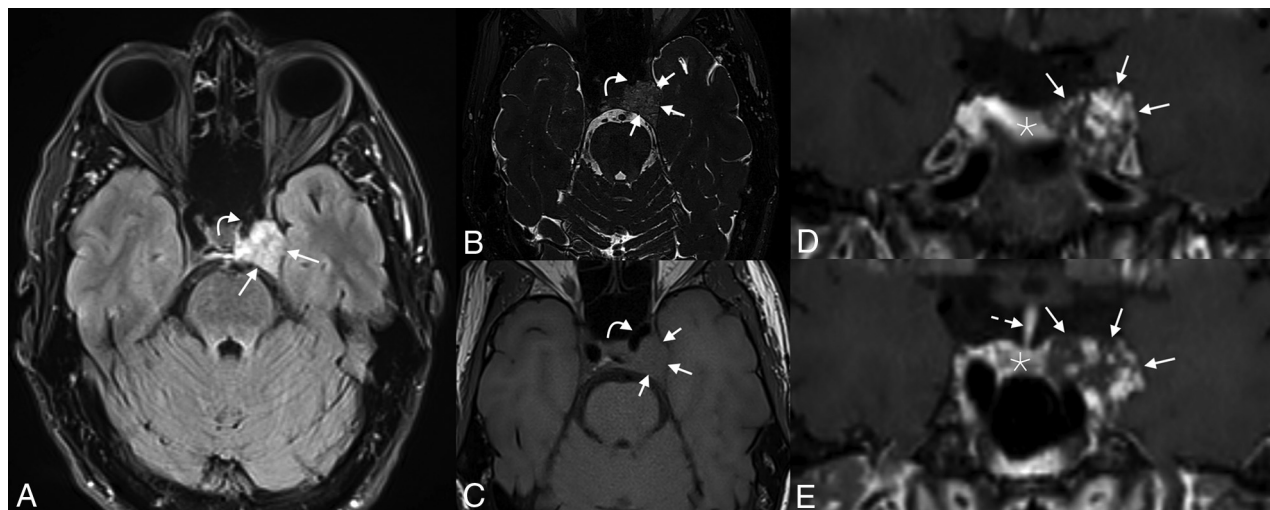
Initial MR imaging of the lesion demonstrates a well-circumscribed mass (*straight arrows*) in the left cavernous sinus with hyperintense signal on FLAIR (A). The left ICA is medialized and encased by the mass (*curved arrows*). Intrasignal signal is notably heterogeneous and coarsened on T2 SPACE (B); enhancement is also heterogeneous (C–E). Coronal postcontrast images delineate encroachment of the mass into the sella, with mild mass effect on the pituitary (*asterisks*); the infundibulum (*dashed arrow*) has slightly deviated to the right.
